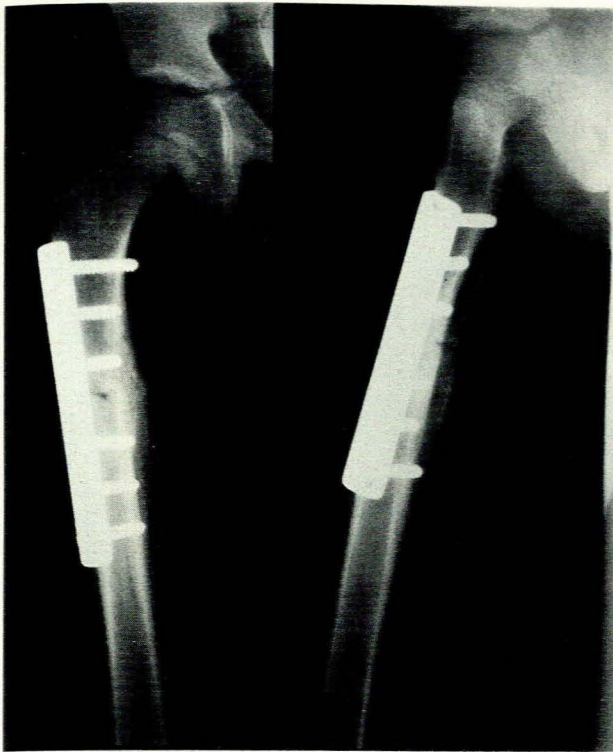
Radiographs 6 weeks after internal fixation of a fracture of the right upper femur in a 6-year-old girl with a head injury. A good position has been maintained and union is advanced.
